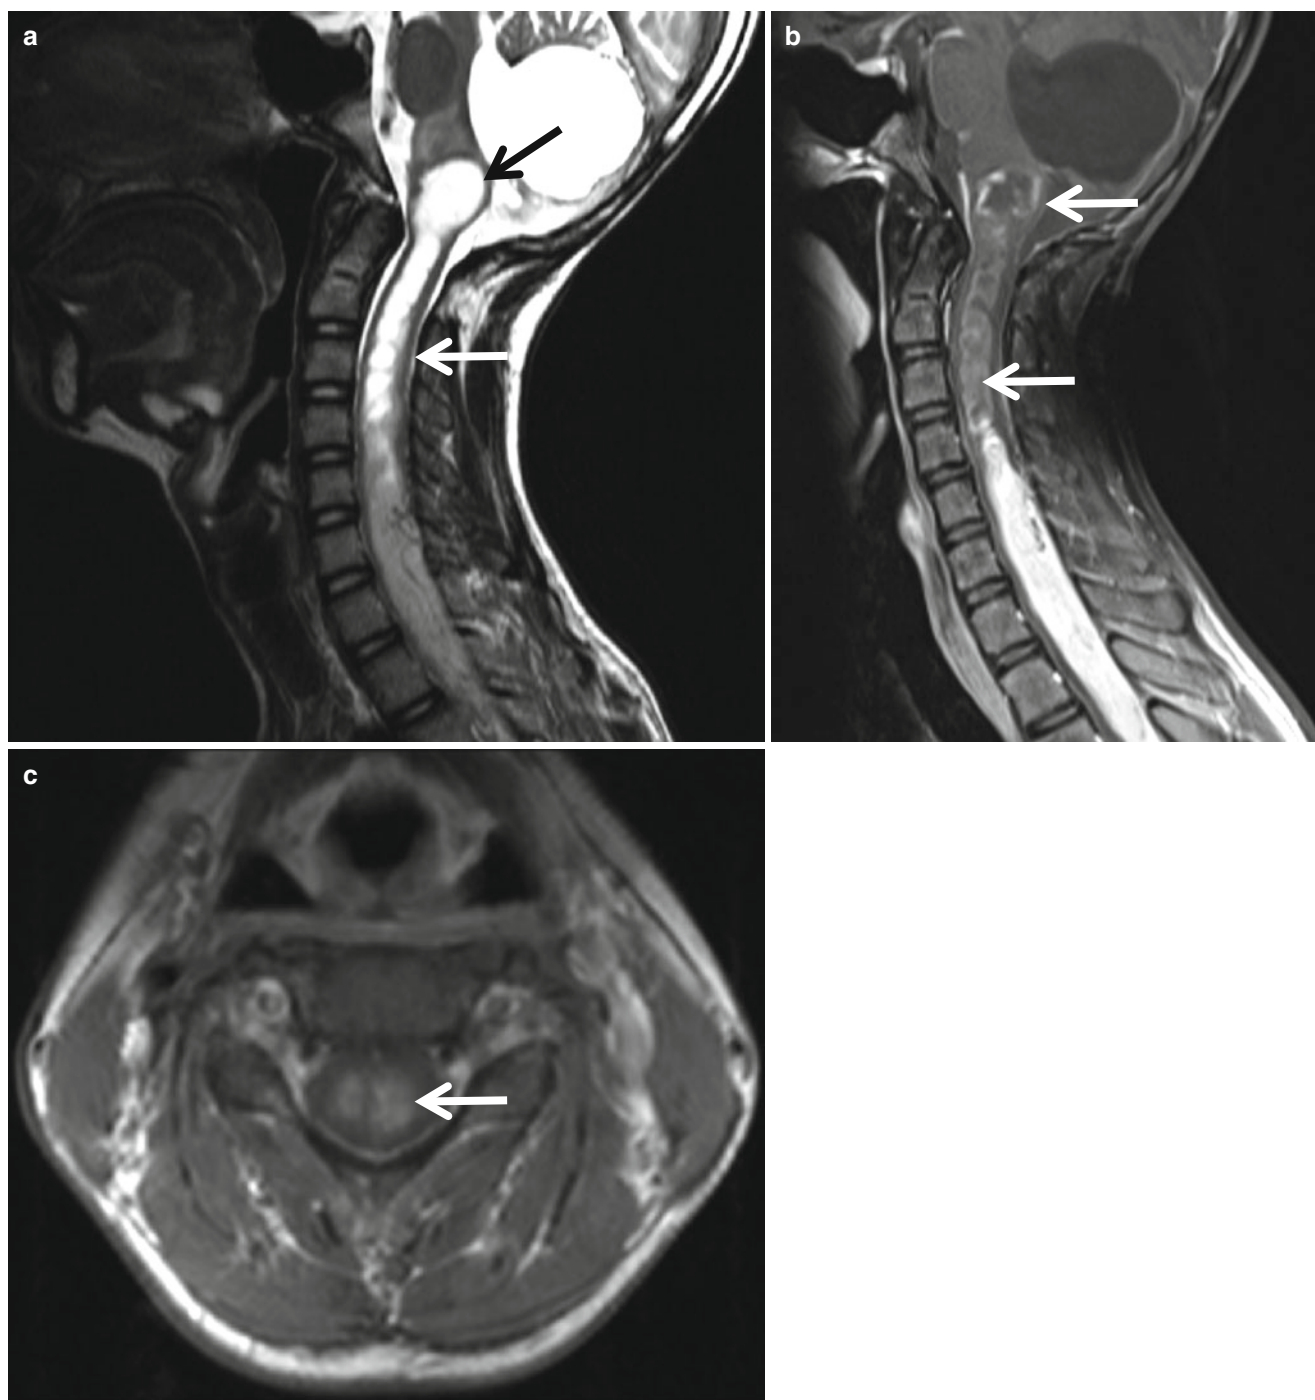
Intramedullary lesion caused by central canal seeding of the medulloblastoma. (a) T2-weighted sagittal image shows hydrosyrinx of the upper cervical cord (*white arrows*), extending upward to the medulla (*arrow*) surrounded by edema, and extensive intramedullary masses. Prior surgical defect is seen in the cerebellum. (b) Lining of the cystic
